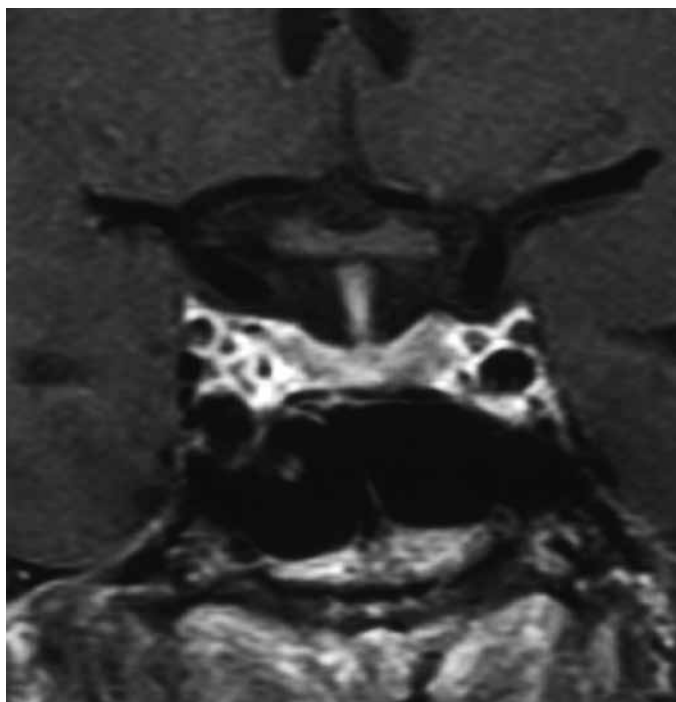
Coronal section of sellar MRI demonstrating heterogeneity in both part of pituitary, predominantly in the left part
